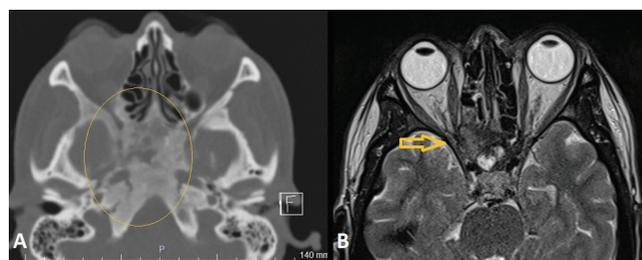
Radiologic images of the patient. Computed tomography of the paranasal sinuses (A) revealed sphenoid bone expansion and ground-glass appearance related to the fibrous dysplasia (yellow circle). On axial T2-weighted magnetic resonance imaging of the orbits (B), the sphenoid bone appeared hypointense and right optic nerve compression caused by obliteration secondary to bony expansion was observed at the level of the optic canal (yellow arrow)
